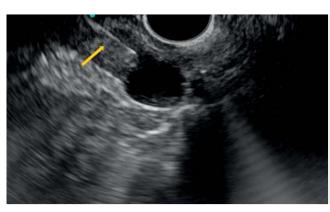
Endoscopic ultrasound-guided fine-needle injection of ink into the parathyroid adenoma. The 25-gauge needle was seen as a hyperechoic line (arrow). 1 mL of sterile purified ink (dilution 0.5:10000) was injected into the nodule and it was seen as a hyperechoic cloud inside the adenoma.
